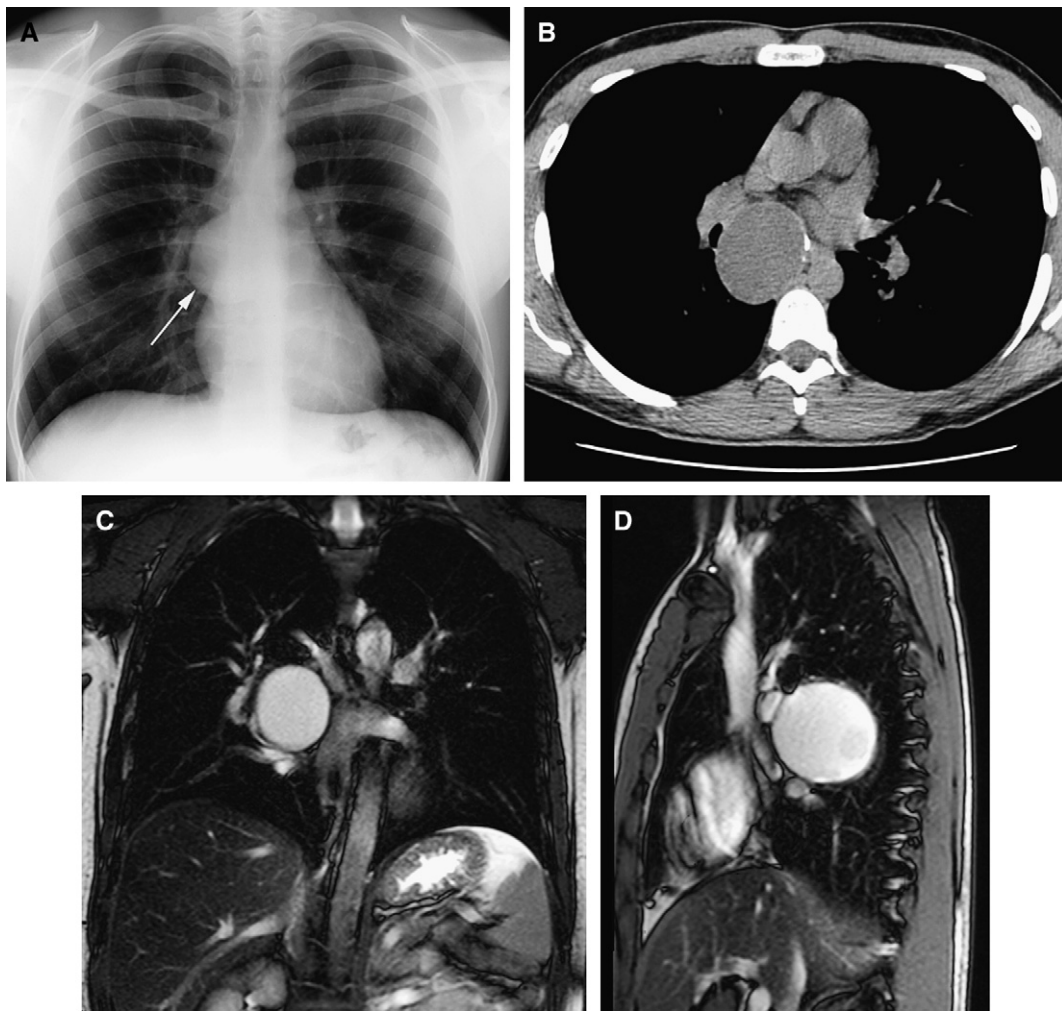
A 43-year-old woman who presented with dysphagia. (A) Chest radiograph, showing a smoothly margined soft tissue density mass beneath the carina (arrow). (B) Transaxial non-contrast-enhanced CT, showing a well-defined soft-tissue attenuation lesion. (C) Coronal and (D) sagittal T2-weighted MRI images, showing a thin-walled, uniformly high-signal lesion in the middle mediastinum.
